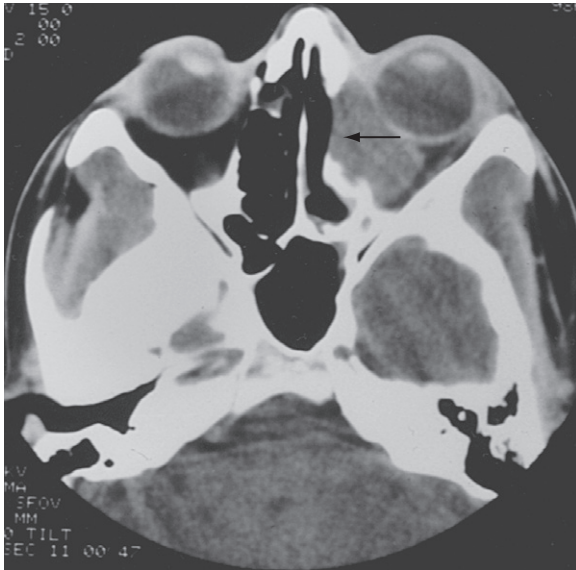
Computed tomography scan of the orbits, revealing the presence of a retro-orbital mass (orbital pseudotumor).
